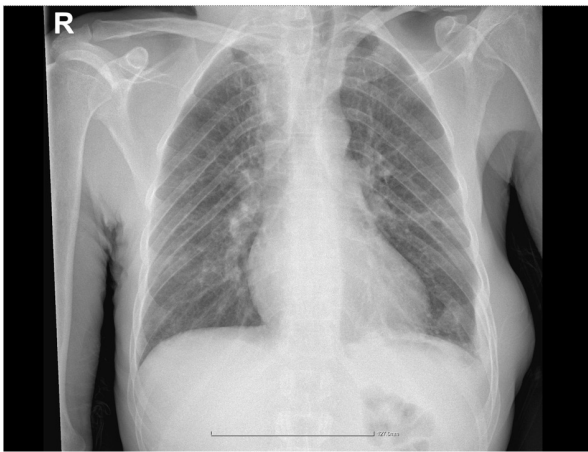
Chest X-ray showing left basal pleural effusion and right upper mediastinum enlargement with tracheal compression. Scale (horizontal bar), 127.6 mm. R, right side.
